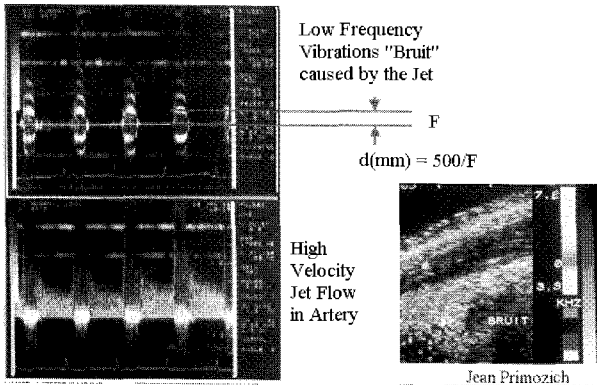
Bruits on spectral and color doppler displays.
